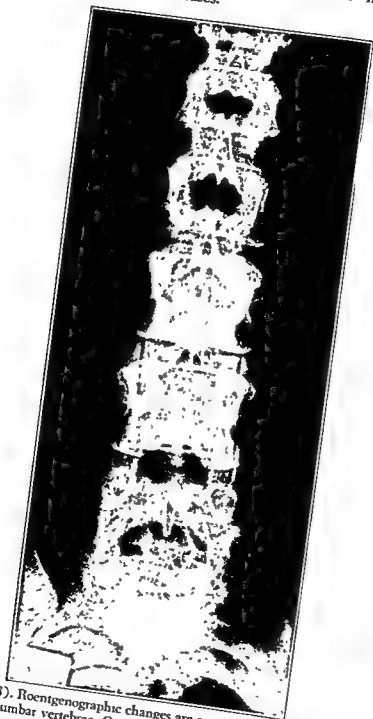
(Case 18). Roentgenographic changes are consistent with pressure on the pedicles of the first to third lumbar vertebrae. Oxygen myelogram showed block at first lumbar level. The diagnosis was neurinoma.
